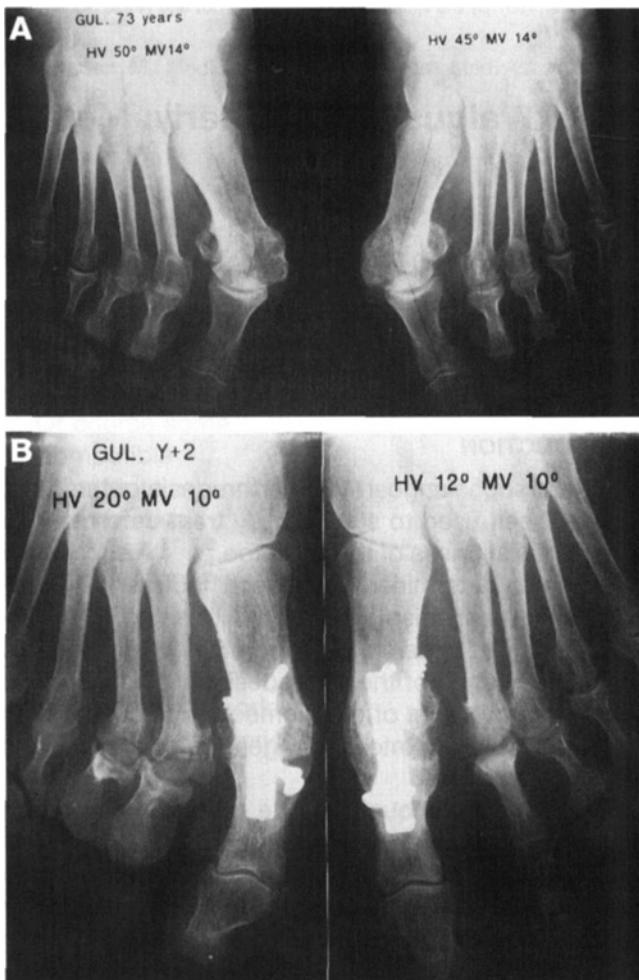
A, Preoperative AP radiographs of a 73-year-old woman. B, Two years after bilateral operation, associating MTP joint arthrodeses and double-stemmed silicone implant for the second and third right lesser toes. On the AP view, good restoration of a 20° hallux valgus on the right side and a 12° valgus of the hallux on the left side.
